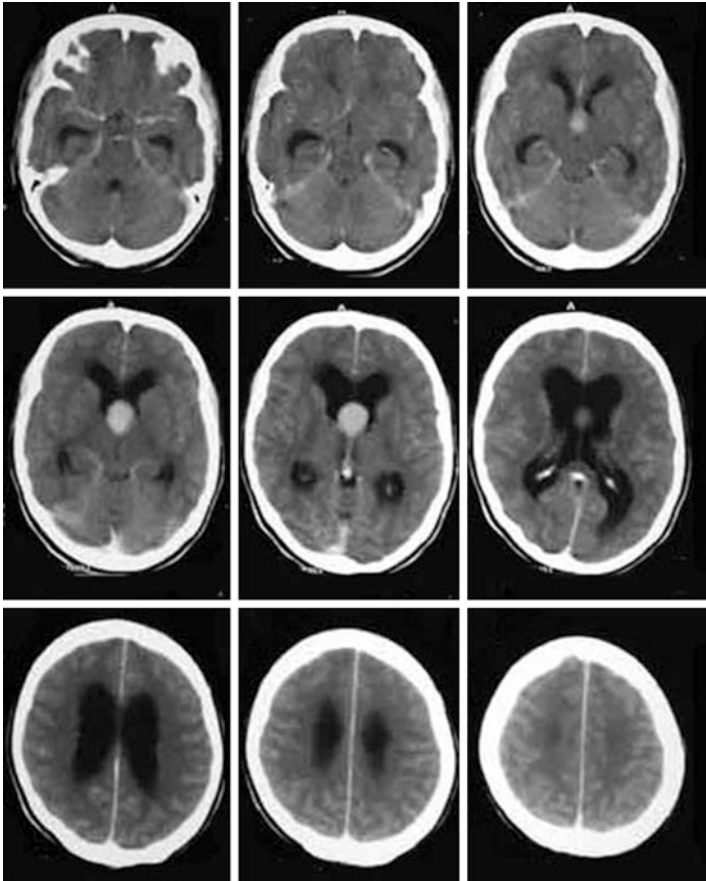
Post-contrast axial CT scan showing an anterior third ventricle colloid cyst blocking both foramina of Munro and causing severe hydrocephalus. Note that the third and fourth ventricles are small or normal because the obstruction is proximal to this level
